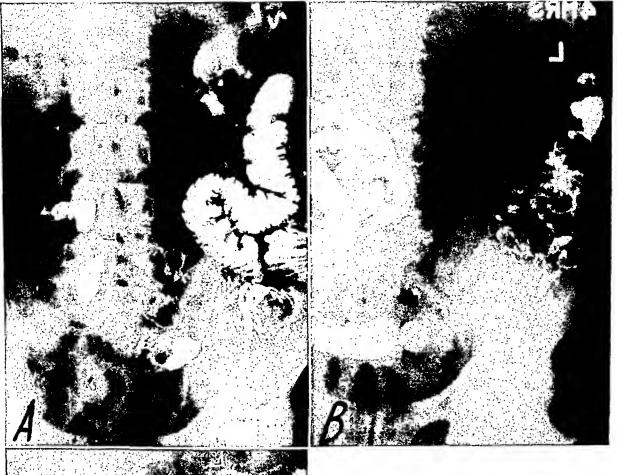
Case II. Roentgenograms made at two (A), four (B) and six (C) hours after ingestion of a barium meal showing the multiple polypoid lesions of the small intestine.
